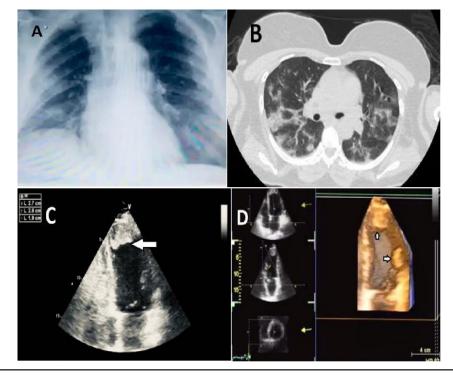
(A-D). A, the Patient's Chest X-ray Revealing Multiple Peripheral Opacities; B, Chest CT Scan Confirming the Findings of X-ray; C, Apical LV Clot in Trans-Thoracic Echocardiography; D, Apical and Lateral LV Clots in 3D Echocardiography.
